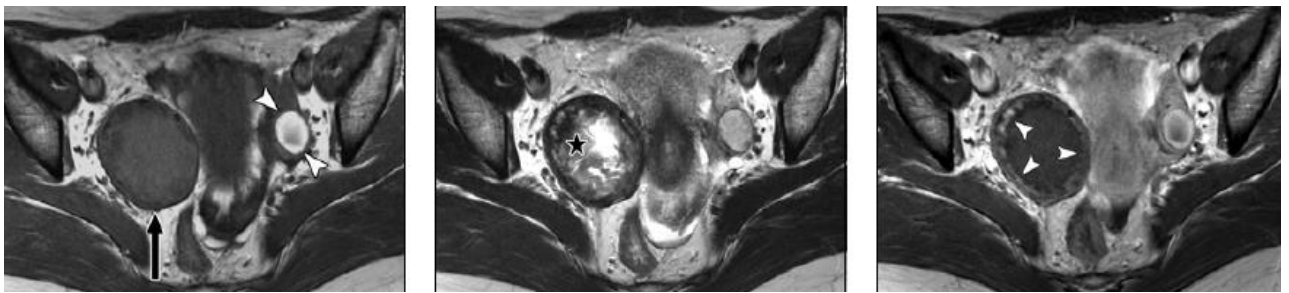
MRI scan showing a low intensity mass with a hyper dense central portion and serrated edges. (111)
